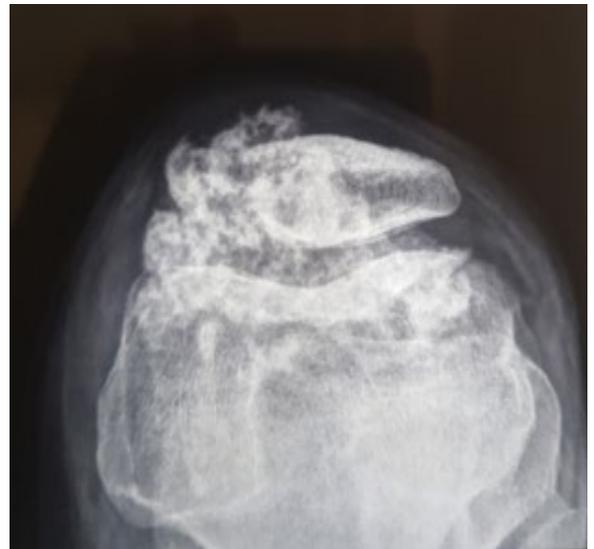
Skyline view radiograph showing a mass medial to patella displacing the patella laterally.
